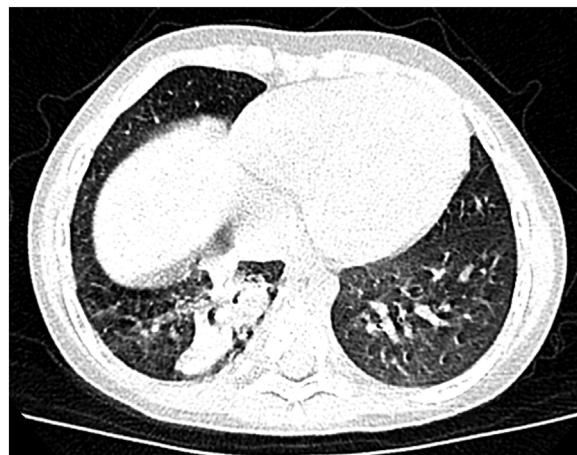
The chest computed tomography (CT) scan of the patient before treatment. CT scan of the chest showed high intensity nodules in the basal segment of the right lower lung lobe.
